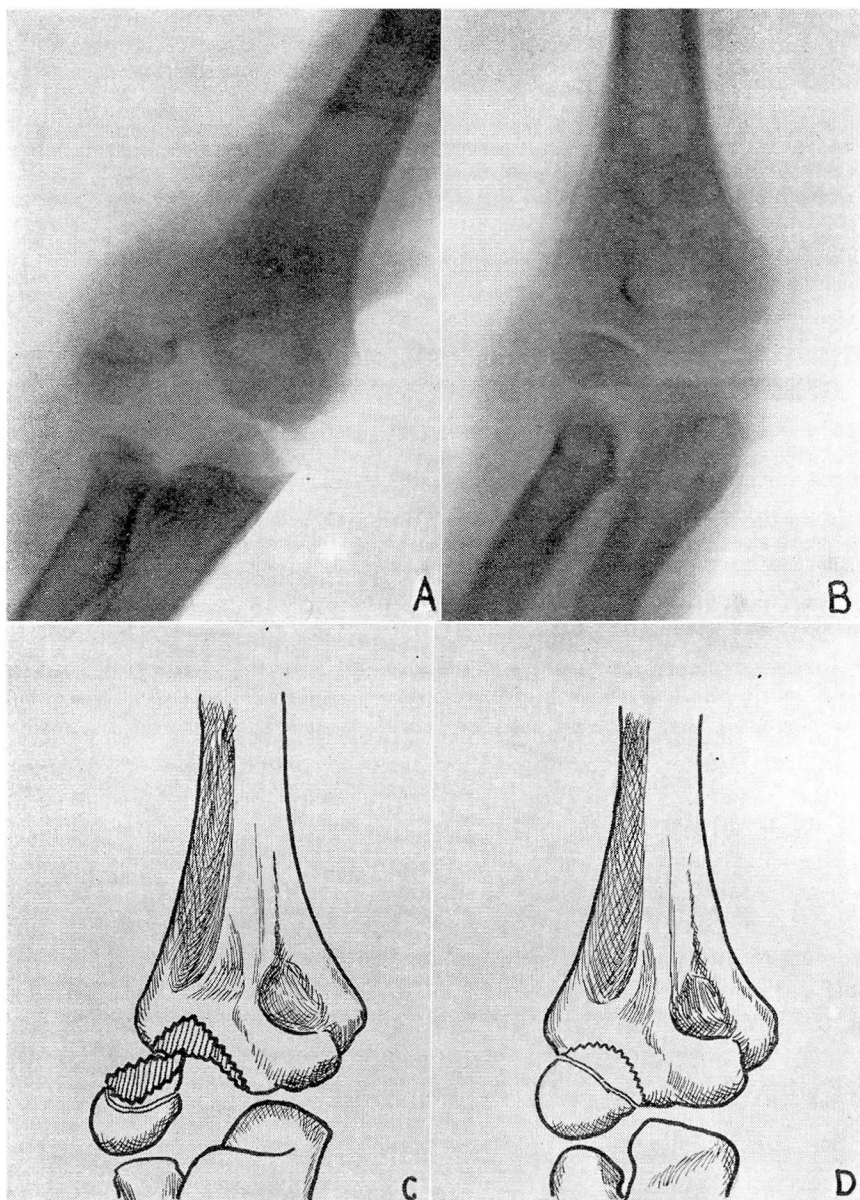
A. Fracture of the external condyle in a boy of six. B. Fracture reduced by open method. C. "Three-dimensional" reconstruction from a tracing of the roentgenogram. D. After reduction.
